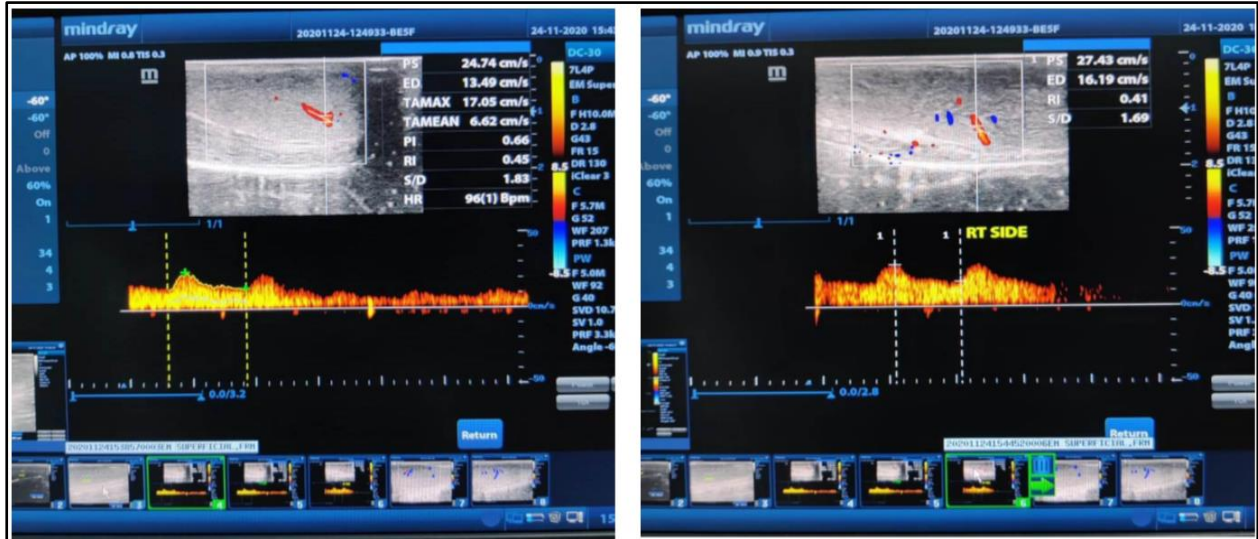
MCU SHOWING ABRUPT CUTOFF IN POSTERIOR URETHRAPENILE COLOUR DOPPLER
